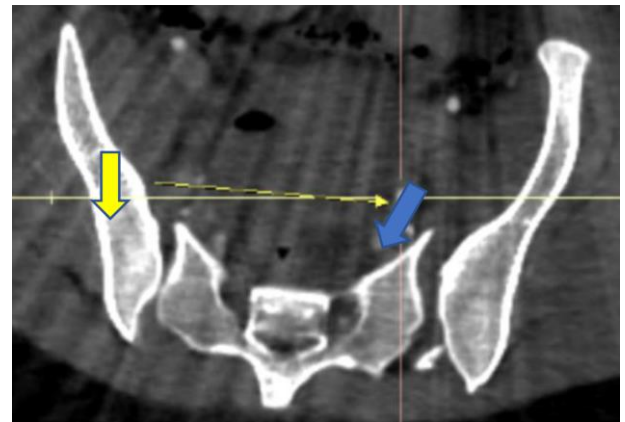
Figure XI(Case two): CT pelvis axial view showing that while the left sacroiliac joint was confirmed to be completely disrupted (blue arrow), the right sacroiliac joint was also partially disrupted anteriorly (yellow arrow).
